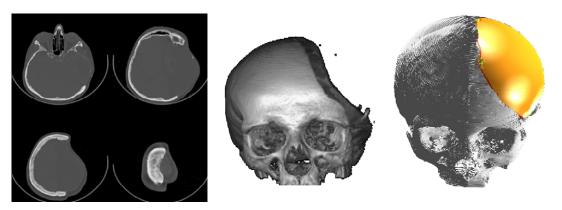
Design of the implant performed in virtual environment. Reconstruction of cranial defect planned from CT images, manipulated in CAD environment. Source: Adapted from Wehmöller et al. (2003).
